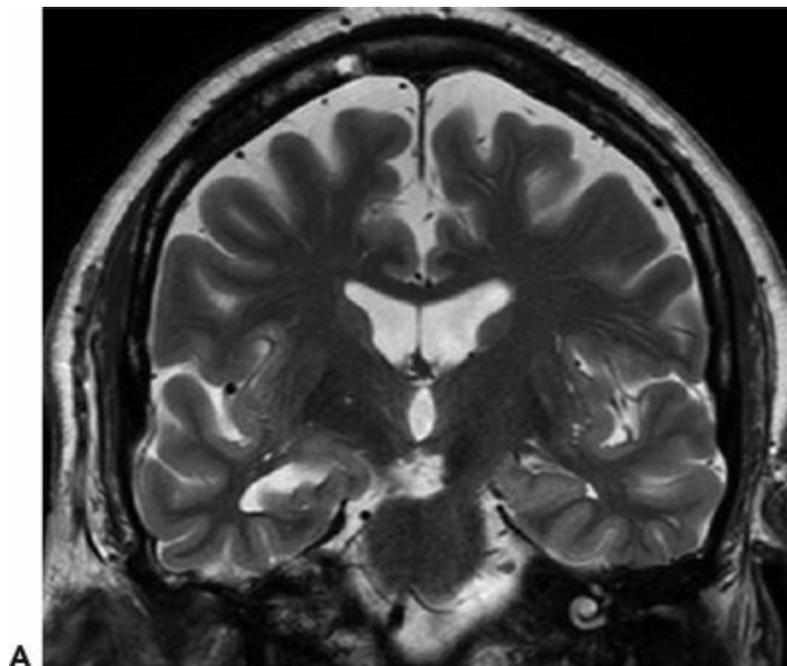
Case history: A 44-year-old man had febrile seizures twice at 2 years of age followed by afebrile seizures. Clinically, he had an aura of dizziness, and then either stared or entered a generalized tonic–clonic seizure. PET showed right temporal hypometabolism. Ictal SPECT (SISCOM) showed right temporal hyperperfusion. He has been seizure free after a right temporal lobectomy. A: Right hippocampal atrophy. B: Ictal EEG 6 minutes after initial onset. One minute later, the patient became unresponsive and entered a generalized tonic–clonic seizure.
